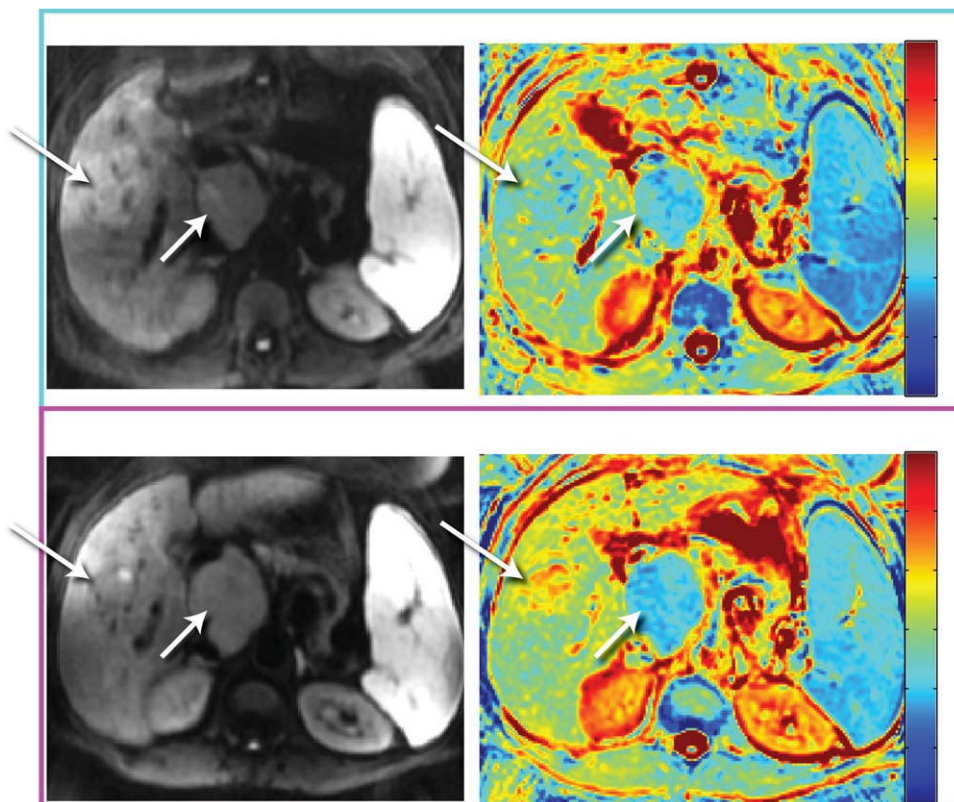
A patient with a hepatocellular carcinoma in the liver undergoing treatment with transcatheter arterial chemoembolization (TACE) (top row) pre and (bottom row) posttherapy. Each set of images consists of the DW-MRI (left images) along with their corresponding color ADC overlay maps (right column).
